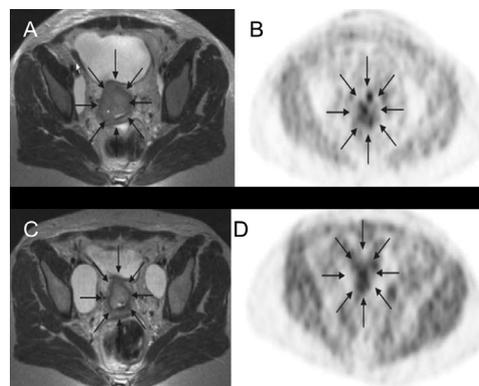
Cervical cancer. Transaxial MRI (left) and FAZA-PET (right) images before therapy (A-B) and during radiotherapy (C-D) in a patient with FIGO stage IIb cervical cancer. Arrows indicate the tumor on the MRI and the hypoxic areas within the tumor. Reprinted with permission.⁵⁸
